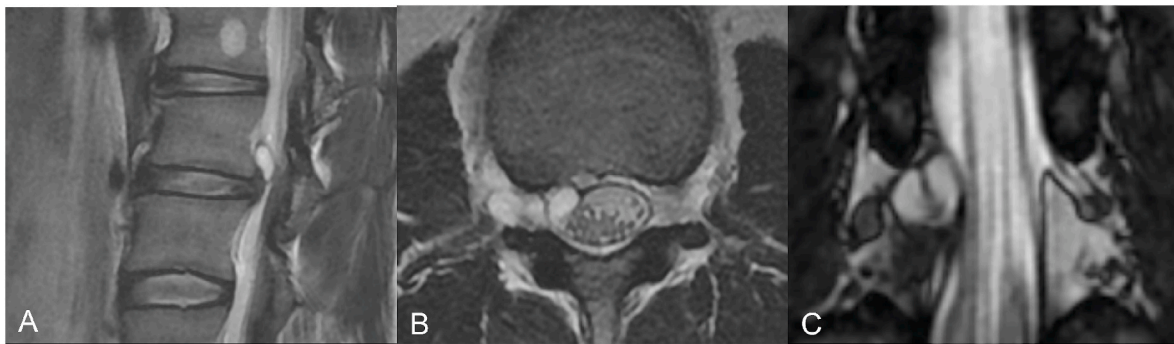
Magnetic resonance imaging (MRI) on T2-weghted images: A, a cystic lesion extends cranially. B, a multilocular cystic lesion extends from the spinal canal to the extraforaminal region. C, a cystic lesion compresses the dural sac and the nerve root.
